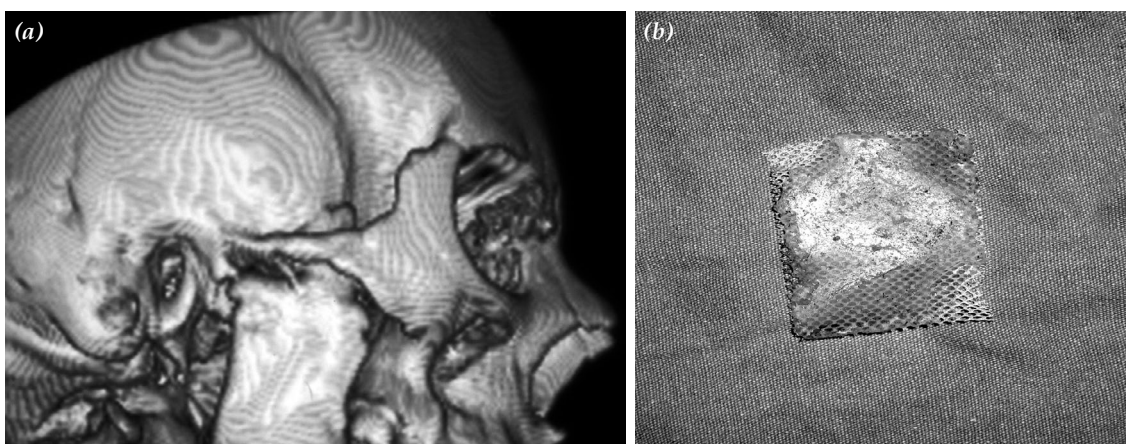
(a) Computed tomographic view of grade 4 bony ankylosis observed in case 2. Note the coronoid process has become united to the temporal fossa, (b) a piece of silicon sheath was removed.
